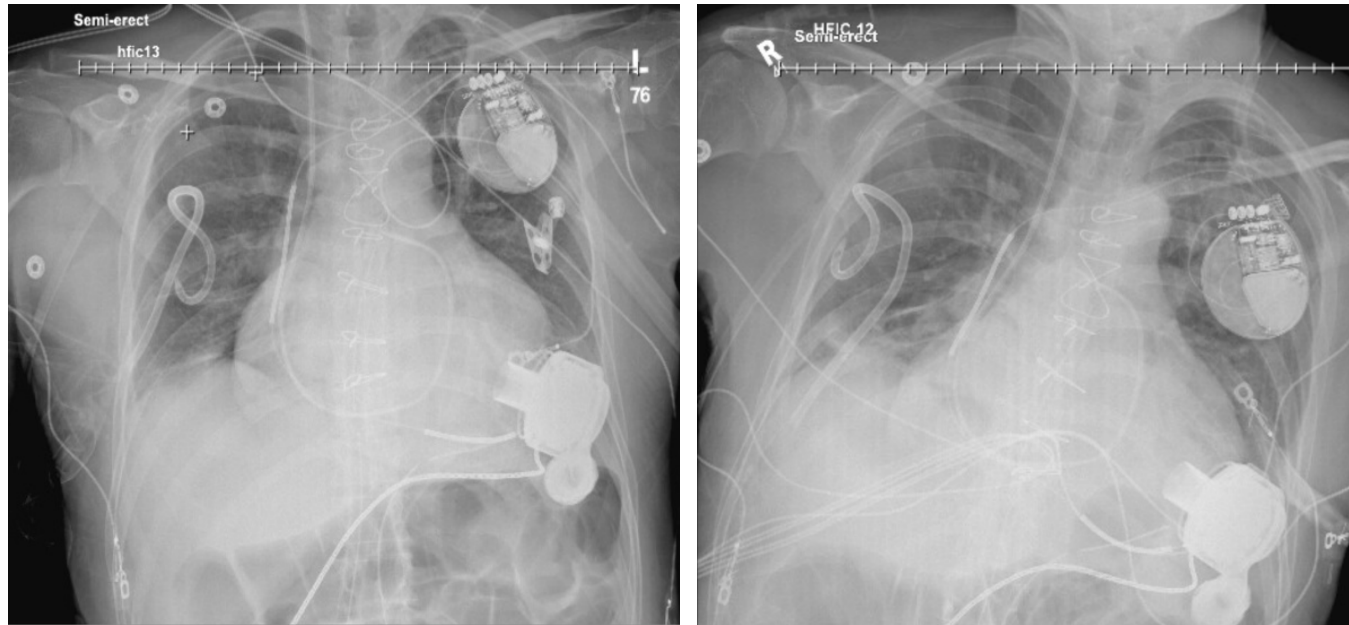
Chest X-Rays (CXR) of patient on POD0 (right) and POD3 (left). POD0 CXR taken on 6/11/23 shows right-sided small pneumothorax not significantly changed compared to prior study. Mild basilar opacities may represent aspiration or atelectasis. No definite right pleural effusion. Trace left pleural effusion. POD3 CXR taken on 6/13/23 shows right-sided small pneumothorax has resolved compared to prior study with no definite perceptible residual. Right basilar opacities are again noted slightly decreased compared to prior study likely represent resolving atelectasis.
